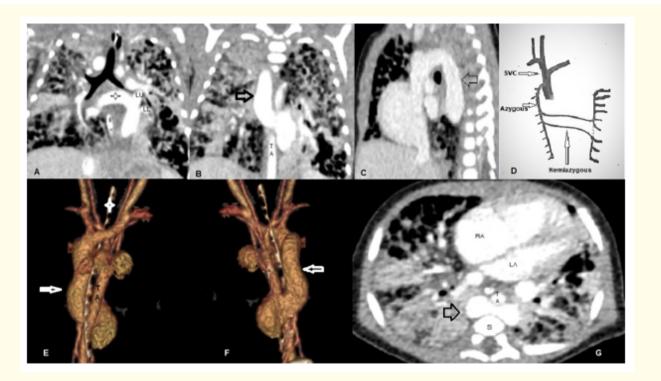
(A) cardiac CT angiogram: coronal view at the level of pulmonary veins showing the confluent, LL = Left Lower
